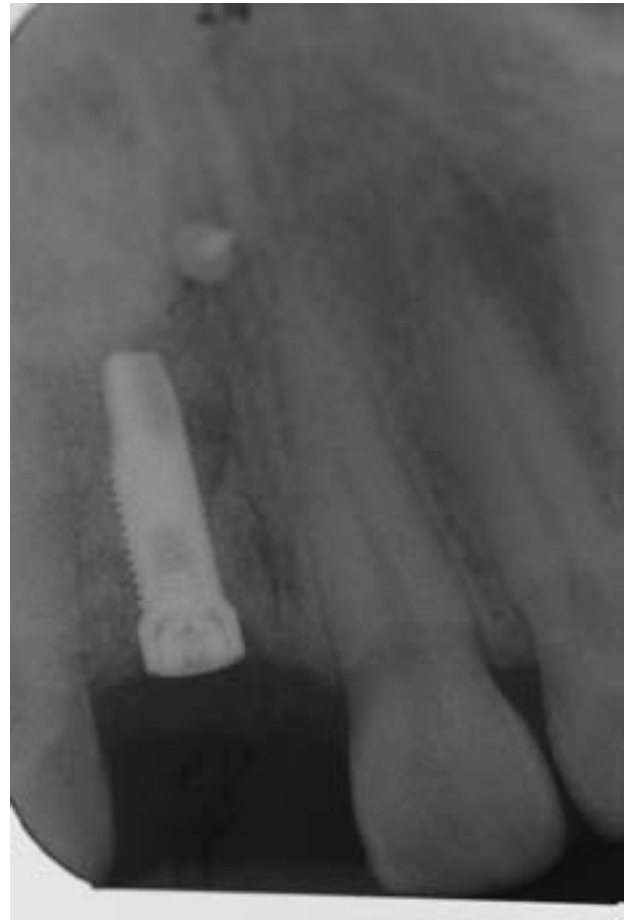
Periapical radiograph after implant placement.
